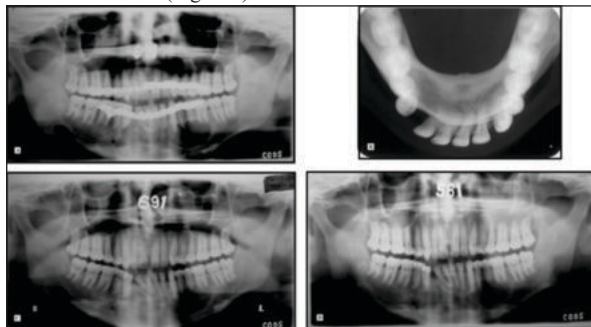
Post-operative radiographs A. Immediate post-op. B and C. Three months post-op. D. Seven months post-op.
